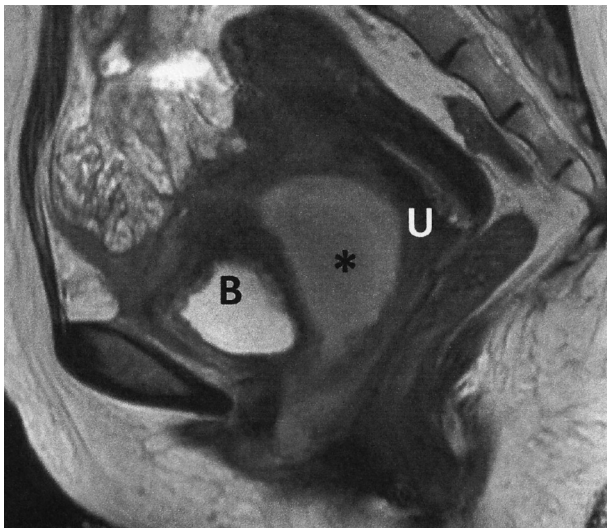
A sagittal T2 weighted MRI shows the abscess (*) between urinary bladder (B) and uterine cervix (U). Uterine cervix is unremarkable.
